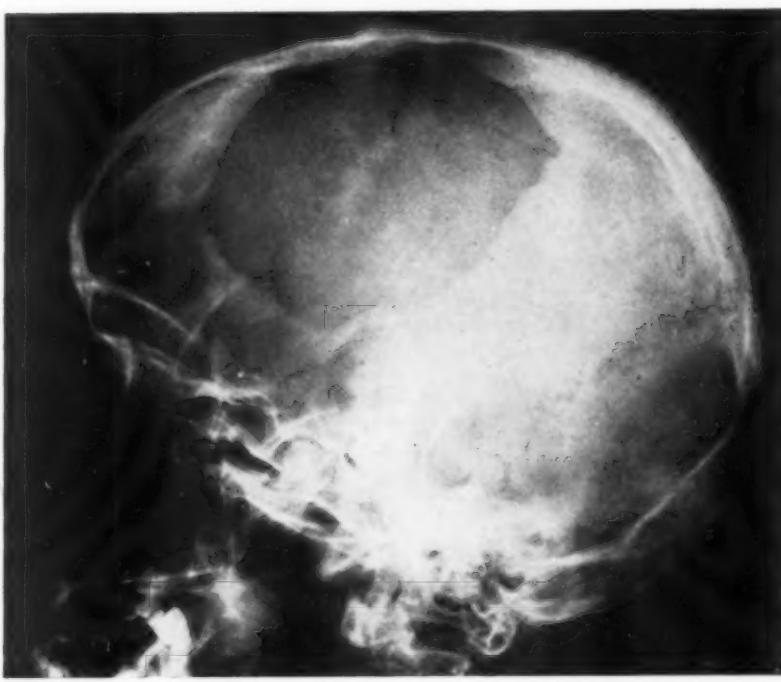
X-ray film showing depression of left temporoparietal region.
